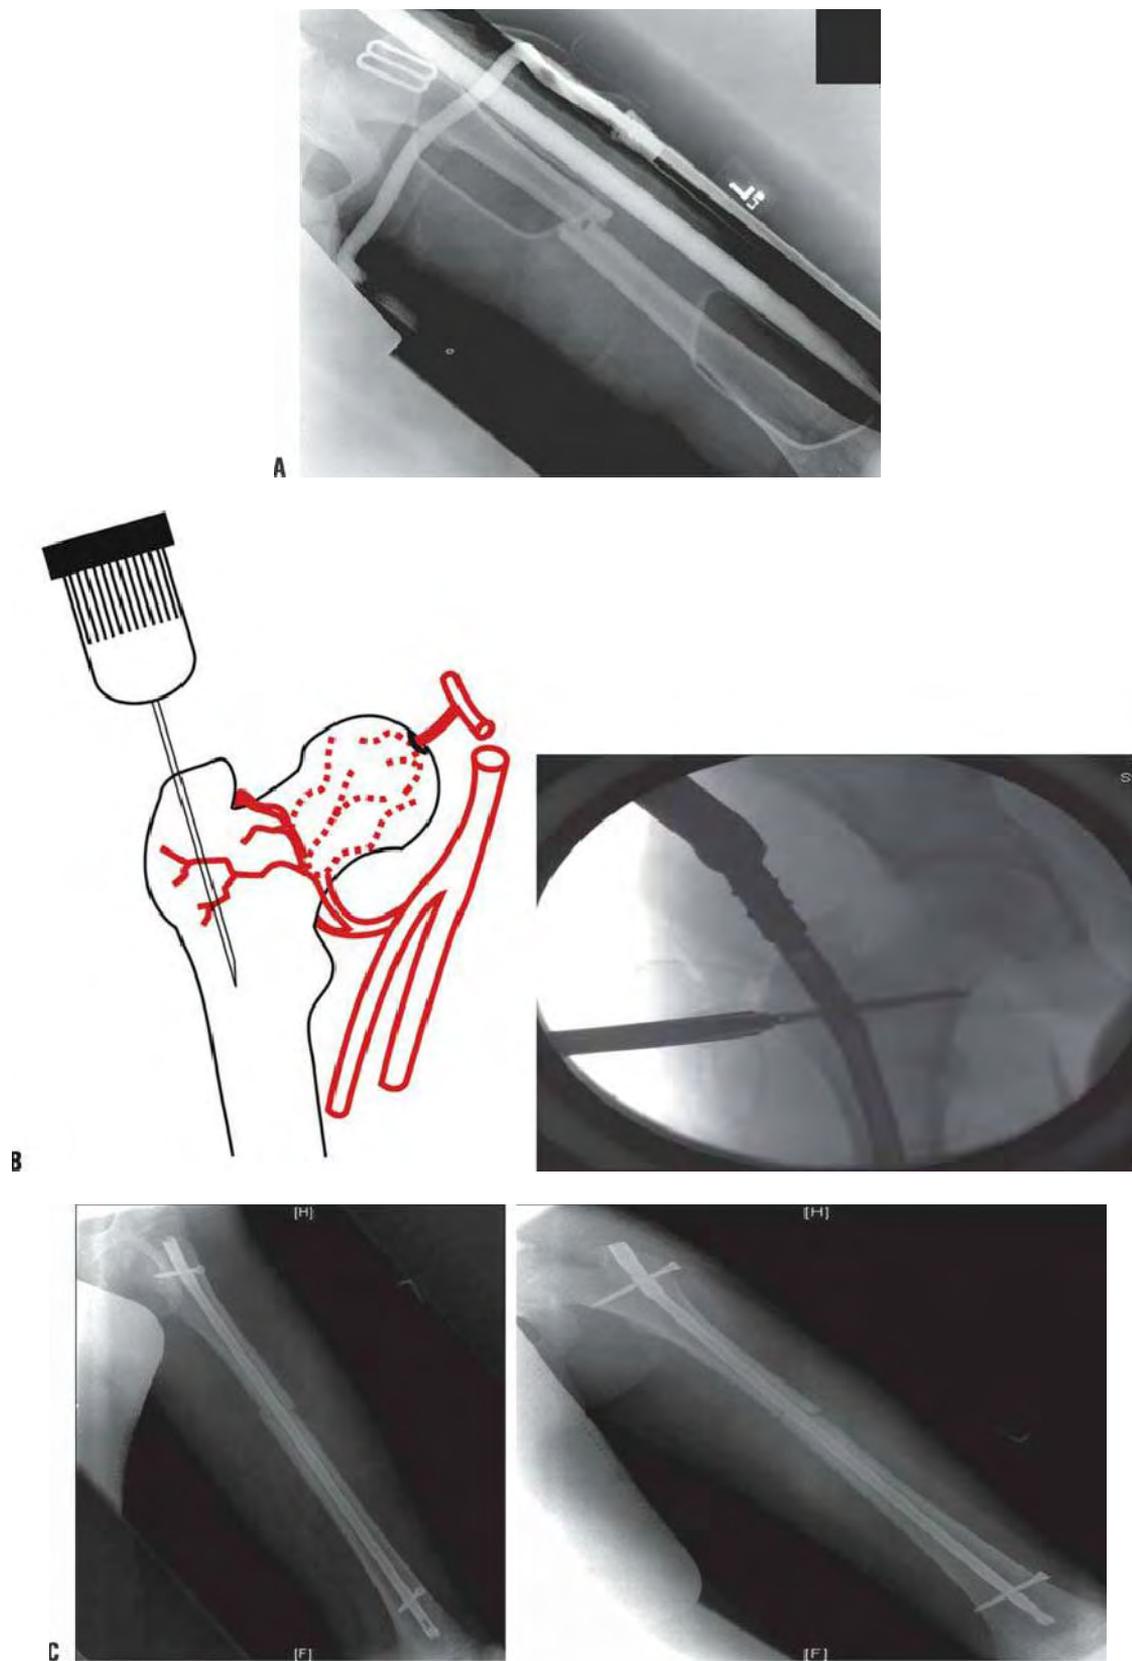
A: A 13-year-old with a transverse diaphyseal femur fracture. Since the patient is older than 11 years trochanteric entry nails were chosen. B: It is important to insert the nail on the lateral trochanter, lateral to the tip of the trochanter to avoid the circumflex artery near the piriformis fossa. (Credit pic to J.D. Bomar.) C: Postoperative radiographs after lateral trochanteric entry intramedullary nail.
